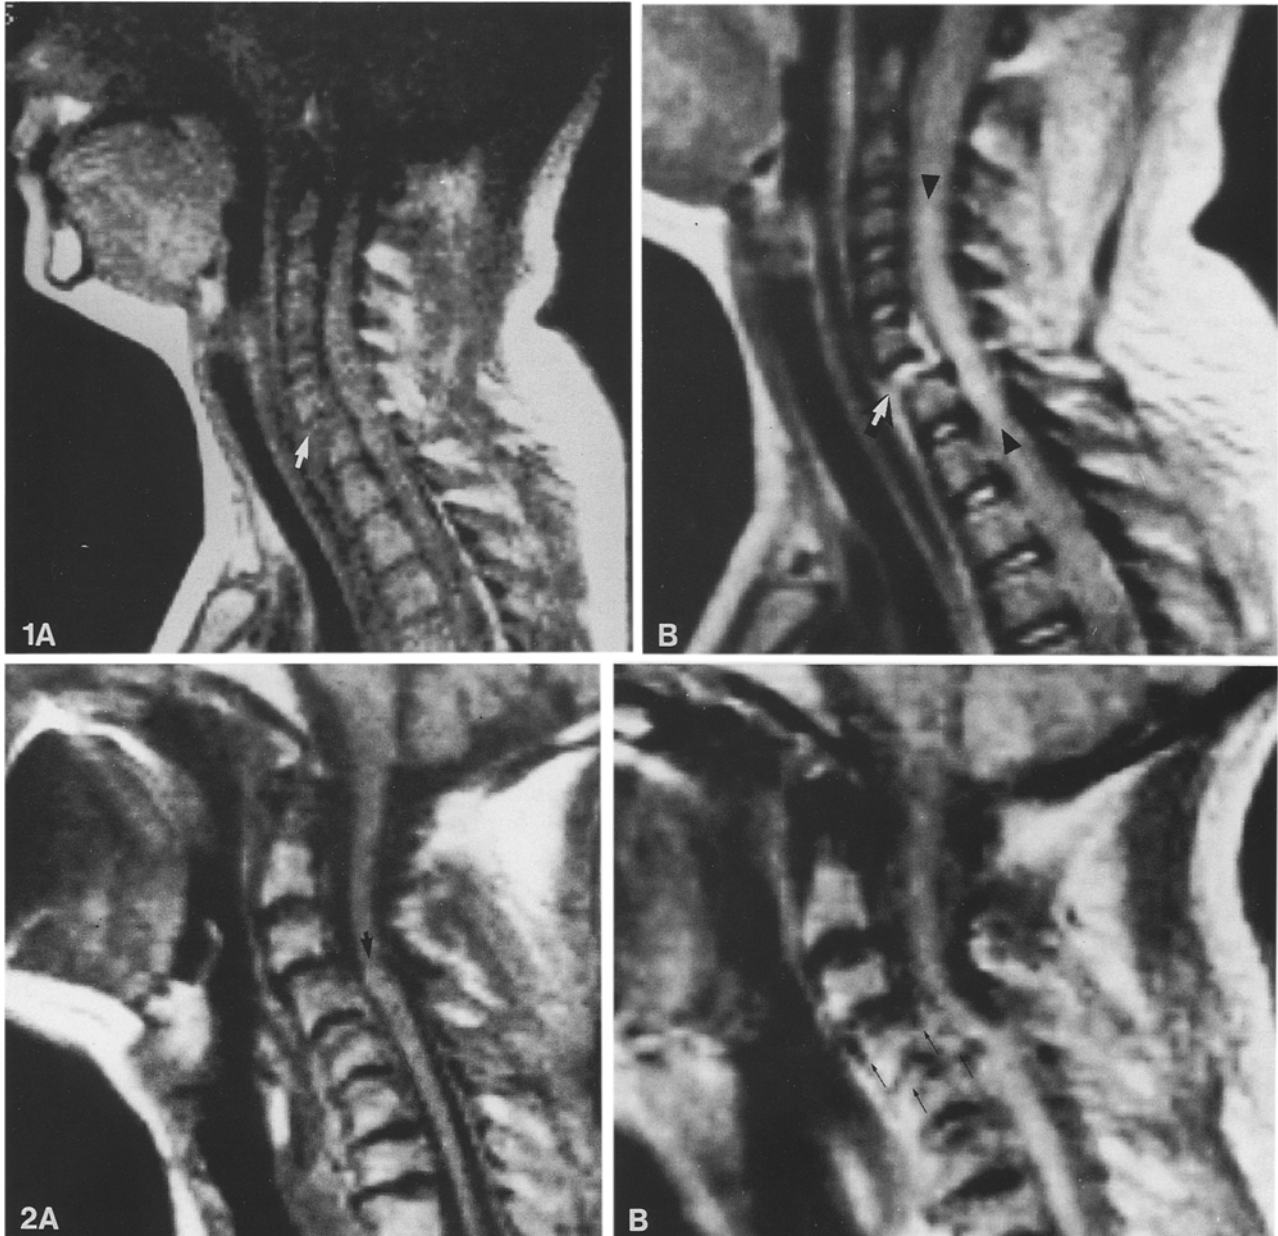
A This midline sagittal image (SE, TR=500/TE=17) demonstrates C6-7 subluxation (*arrow*). The anterior aspect of the adjacent cervical cord is buckled, and the overall cord contour is swollen. B More precise detail at the fracture site can be gleaned from this more strongly T2-weighted scan (SE, TR=2100/TE=35). Burst fragment from the posterosuperior aspect of C7 is clearly appreciated. The C6-7 interspace is gapping, and the anterior longitudinal ligament is disrupted (*arrow*). Hyperintensity compatible with hemorrhage/edema is noted within the cord spanning the injury site (*arrowheads*)
